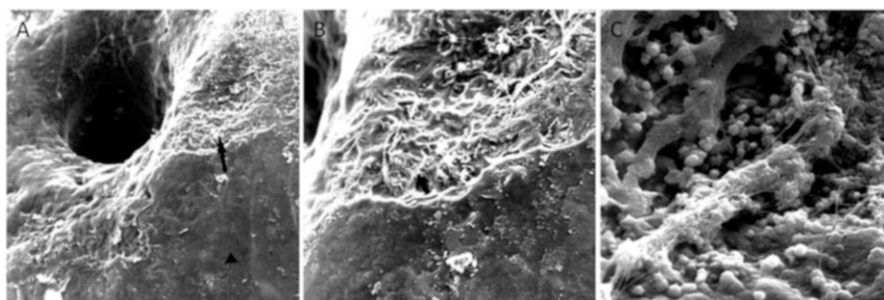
External surface of the root apex of tooth with pulp necrosis and chronic periapical lesion. (a) Morphological changes in the radicular cementum close to the apical foramen showing areas of intact cementum (*arrowhead*) between areas of resorption (*arrow*) ($\times 400$). (b) Higher magnification of cementum resorption in (a) with areas of microorganisms (*arrow*) ($\times 1650$); (c) Higher magnification of (b) (*arrow*), showing the presence of cocci forming apical biofilm ($\times 6000$) (Reprinted from *Journal of Endodontics*, 28(12), Leonardo MR, Rossi MA, Silva LA, Ito IY, Bonifácio KC. EM evaluation of bacterial biofilm and microorganisms on the apical external root surface of human teeth, 815–818, ©2002, with permission from Elsevier)
